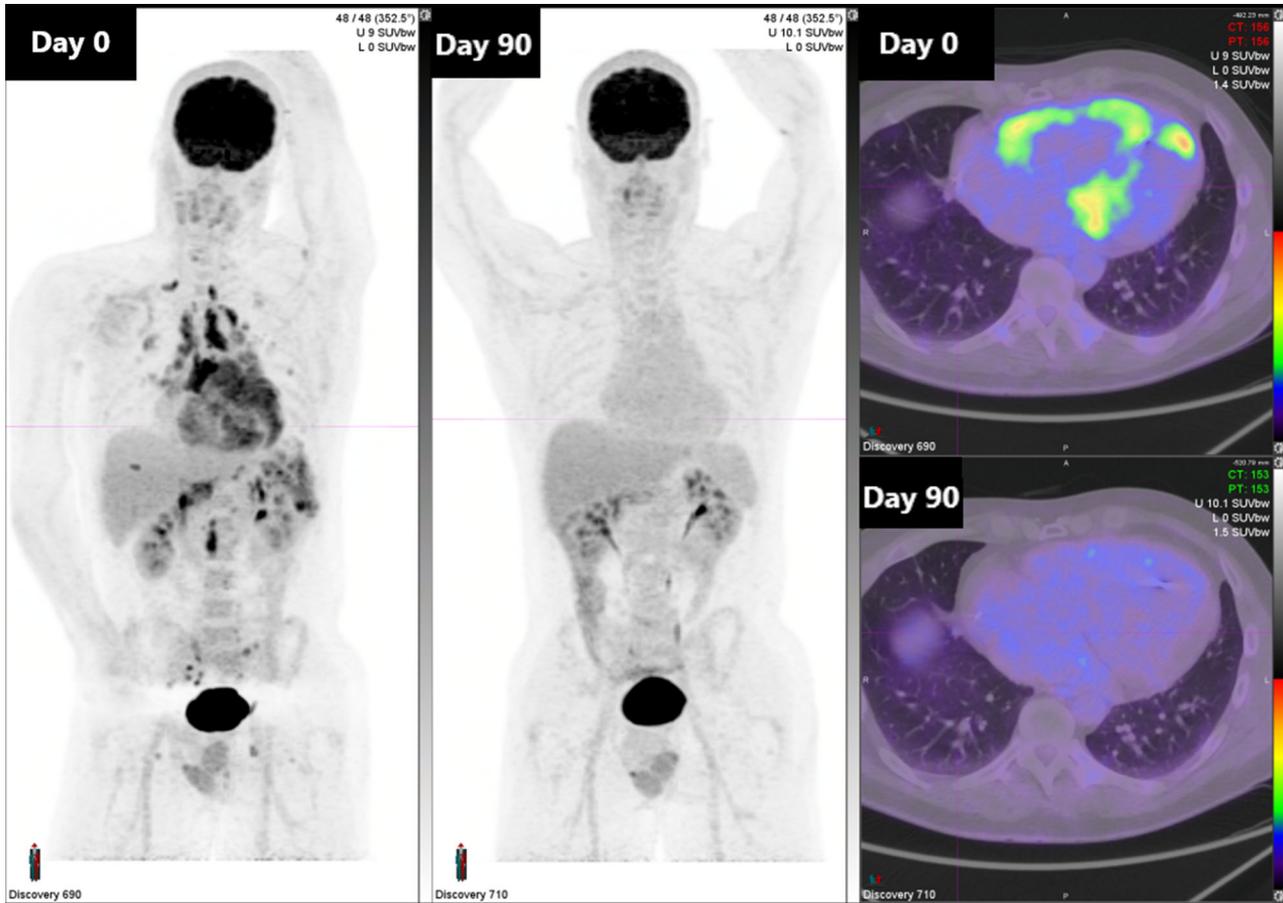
Comparative PET images. Comparative PET scans at 0 and 3 months. The repeat PET scan at 3 months was normal, with complete resolution of pathological FDG uptake (including cardiac).
